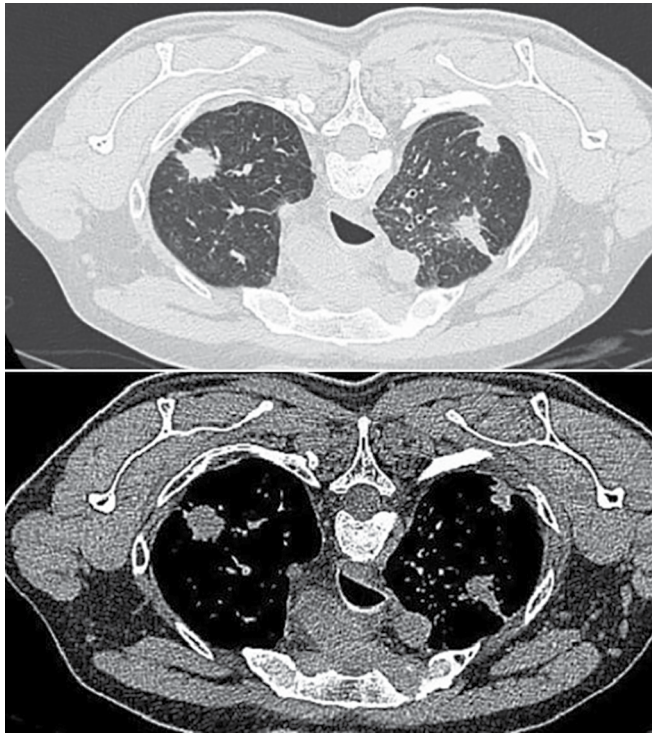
Contrast-enhanced CT thorax images showing multiple irregular soft tissue nodules with spiculated margins and surrounding ground-glass opacities in bilateral lung fields
